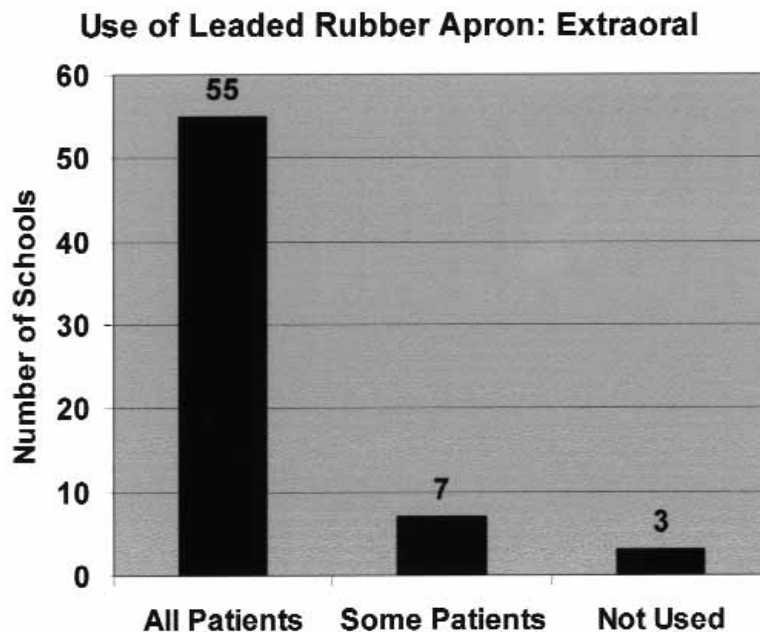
Use of leaded rubber aprons in extraoral radiographic procedures.
